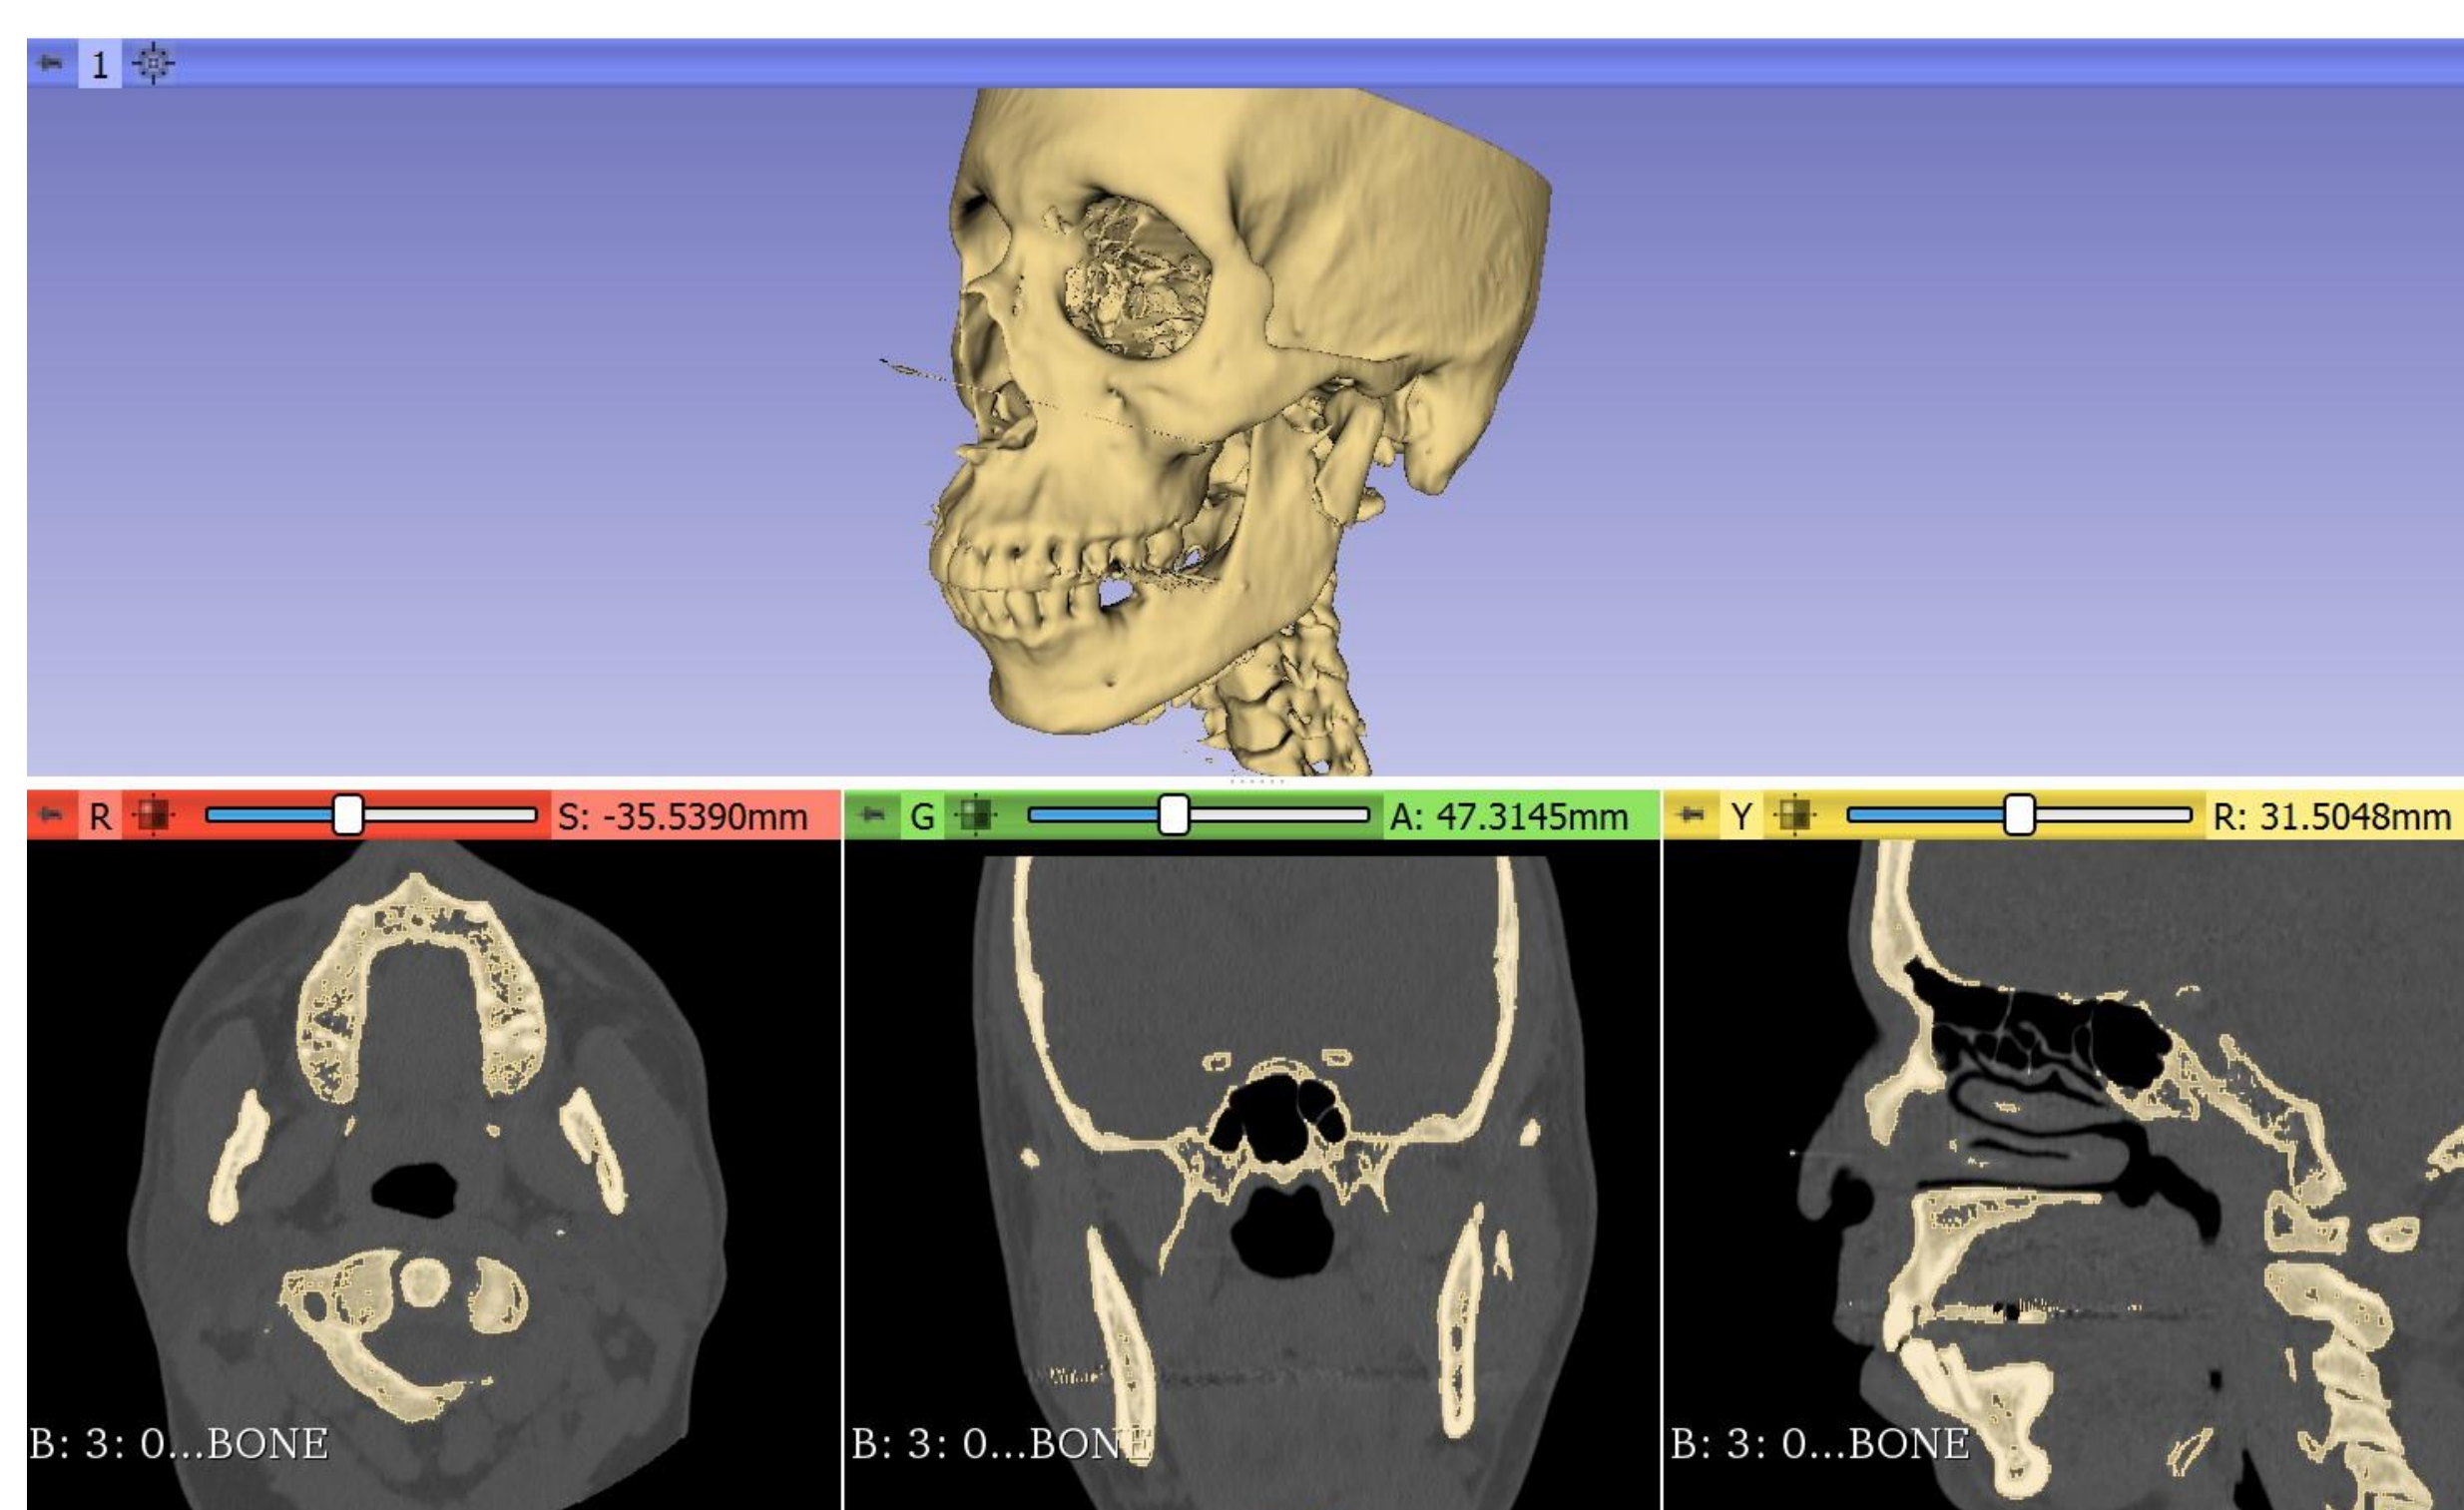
Bone segmentation. 3D Slicer is used to segment the patient's bony structures from their CT scan.
